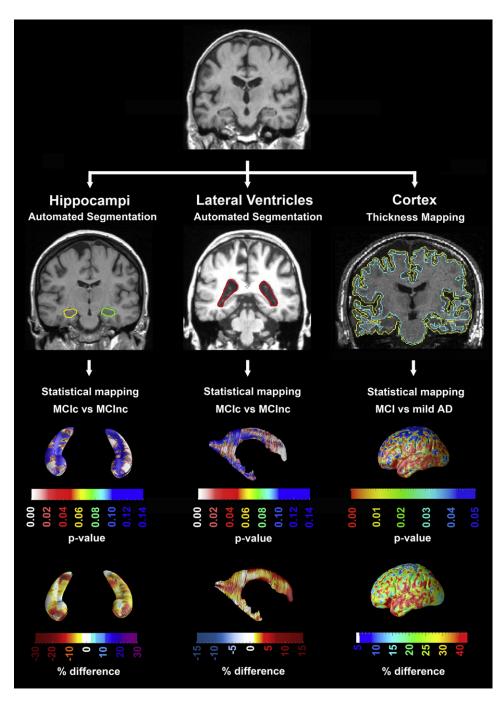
MRI with 3D structural reconstruction to show hippocampal atrophy (left column), ventricular enlargement (center column), and cortical thickness (right column) (images courtesy of Liana Apostolova, MD and Kristy Hwang, UCLA) (AD, Alzheimer's disease; MCIc, mild cognitive impairment that converted to AD; MCInc, MCI did not convert to AD).
